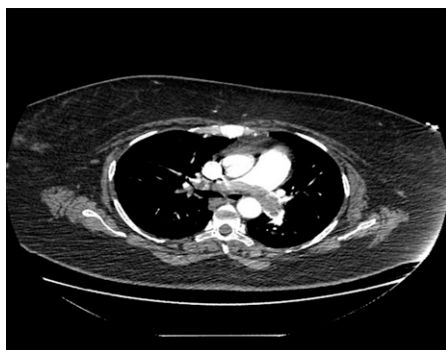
Computed tomographic angiogram showing saddle pulmonary embolism.
